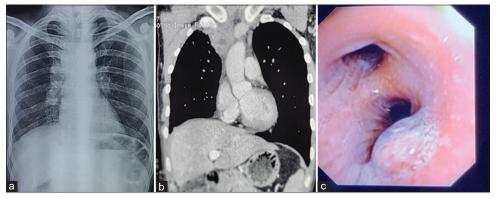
(a) Chest X-ray suggestive of the right upper lobe collapse, (b) CECT thorax suggestive of right upper lobe collapse with enlarged mediastinal lymph nodes, (c) bronchoscopic image showing polypoidal growth in the right upper lobe bronchus
